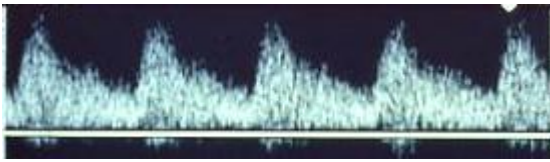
The normal hepatic artery Doppler spectral waveform is characterized by rapid systolic upstroke and constant forward diastolic flow.
